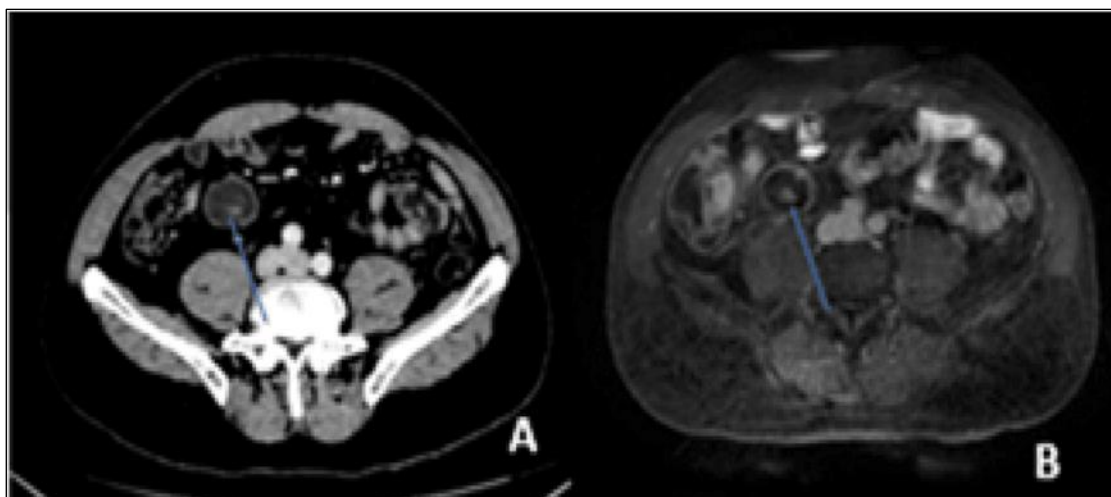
Axial contrast-enhanced CT (A) and axial fat-suppressed T1-weighted post-contrast MRI demonstrating a nodular enhancing component within the appendiceal lesion (arrow).
